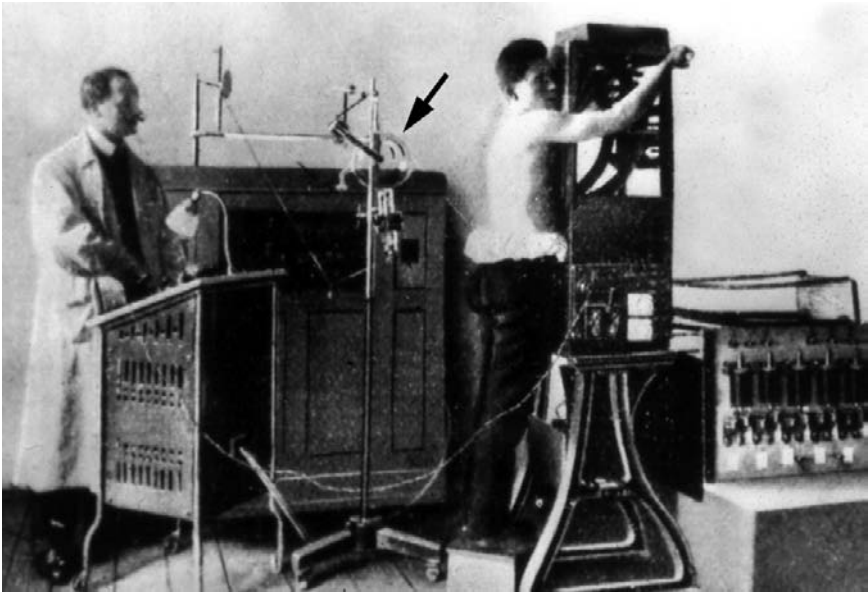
An early photograph, probably late 1890s, of a chest x-ray being taken in Glasgow Royal Infirmary. Note the x-ray tube (arrowed) is completely unshielded, and is bathing the whole room in x-rays. Image courtesy of NHS Greater Glasgow and Clyde Archives.
